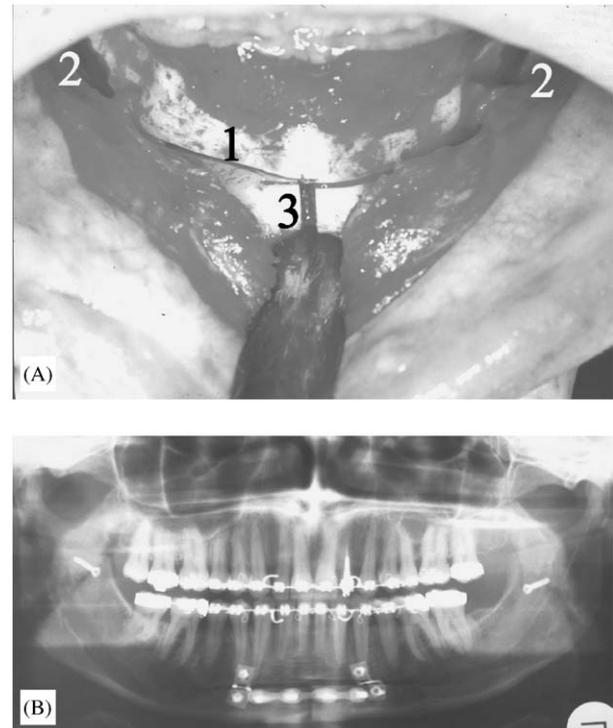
Modified technique for dentoalveolar mandibular advancement. (A) Anterior view. The symphyseal osteotomy allows the mandibular base ‘wings’ to be spread, resulting in easier mobilization of the dentoalveolar segment, and direct visual control of lingual interferences. (1) Anterior subapical horizontal osteotomy, (2) bilateral ‘long’ sagittal split osteotomies, joining the horizontal osteotomy below the mental foramen, (3) median vertical symphyseal osteotomy. (B) Orthopantomogram after fixation with two meshplates, a median miniplate and bicortical screws in the ascending rami.
